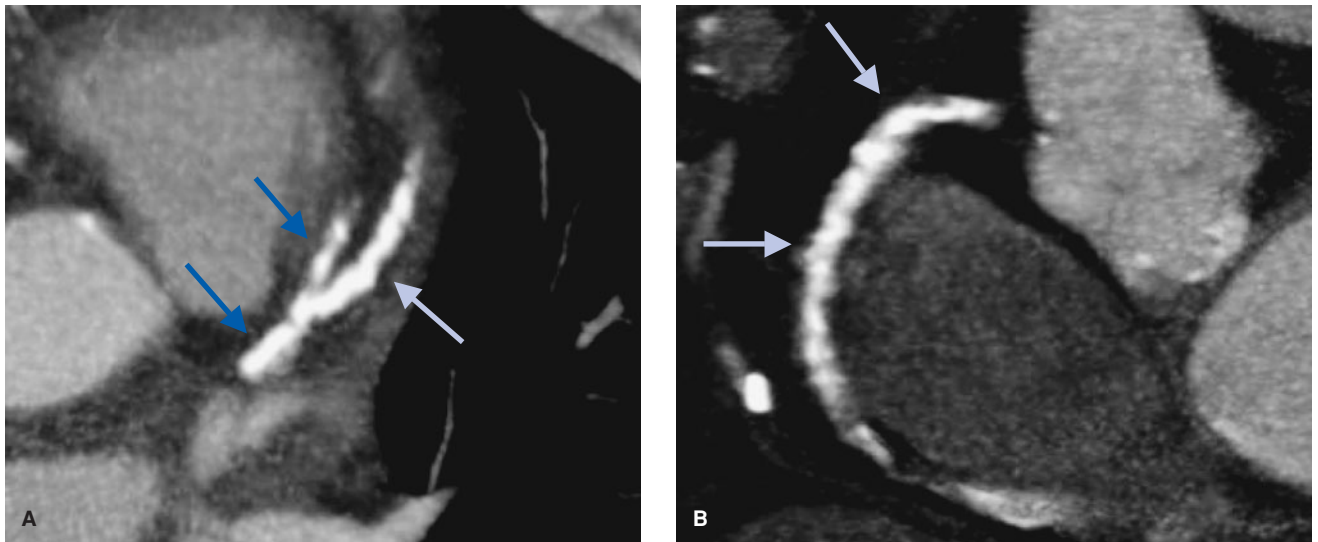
Cardiac CT often is limited in its evaluation of native coronary arteries in the post-CABG patient owing to the presence of advanced and heavily calcified coronary atherosclerosis. Double oblique maximum-intensity projection image (4 mm) demonstrates (A) the proximal LAD (blue arrows) and a large first diagonal branch (gray arrow) and (B) the proximal right coronary artery (gray arrows). The white areas represent calcification. All vessel segments shown are heavily calcified. The extent of calcification completely obscures the vessel lumen, and the presence or absence of stenosis cannot be assessed reliably.
